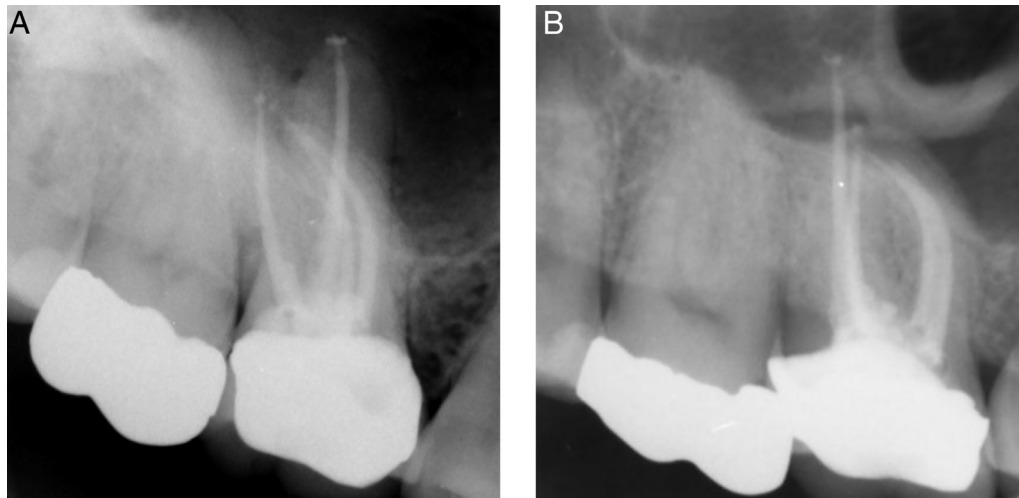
Postoperative radiographs are shown of the (A) final root canal treatment and (B) after 2 years.
